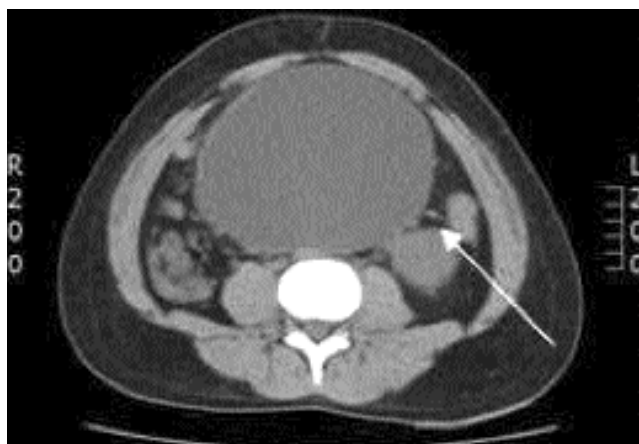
CT scan showing a very large abdominal cystic mass compressing the left ureter (arrow).
